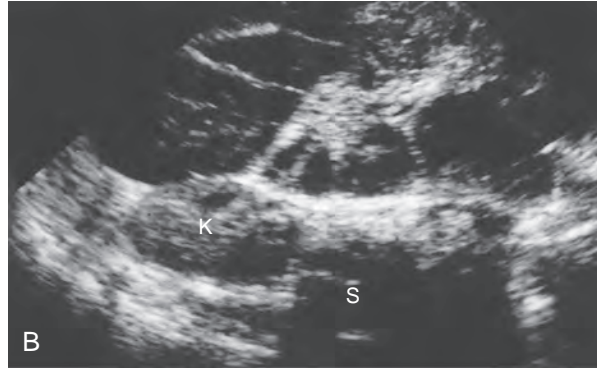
Neonatal abdominal mass: mesenteric lymphangioma. A. Barium is present in the stomach, duodenum, and small bowel. Gastroesophageal reflux is filling the distal esophagus. The duodenal sweep is displaced to the left. Upwardly displaced, compressed, and opacified bowel loops are seen in the right upper quadrant. B. Transverse abdomen sonogram to the right of the midline demonstrates multiple, fluid-filled structures. None of these structures had visible peristalsis because they were portions of the lymphangioma. K, Kidney; S, spine.
